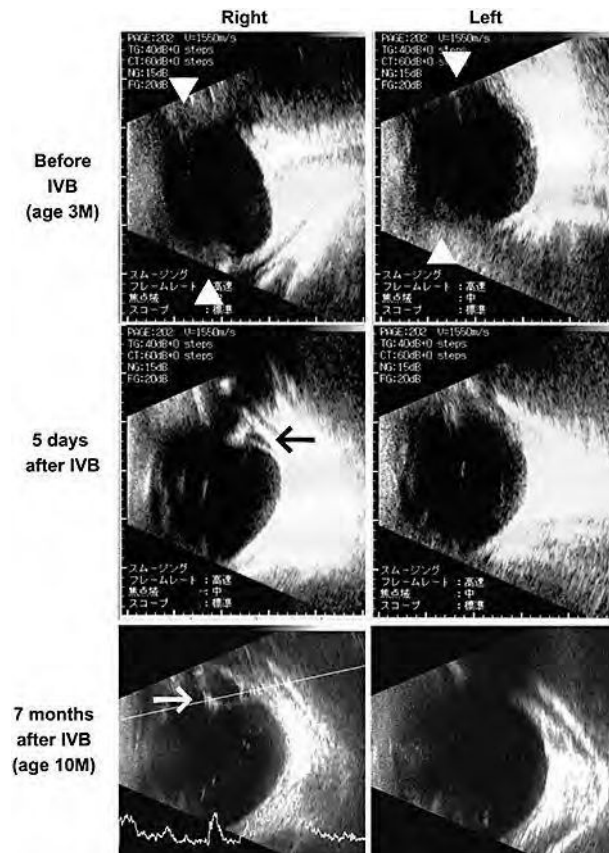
Ultrasonographic findings of eyes with Peters anomaly and ROP. Before the IVB, abnormal echo was detected which suggested ridge formation (triangles in the upper row, stage 3 ROP). Five days after the IVB, a retinal detachment was suspected in the right eye (black arrow in the middle row, stage 4A ROP). Seven months after the IVB, a third retinal detachment is suspected in the right eye (white arrow in the lower row, stage 4A ROP).
